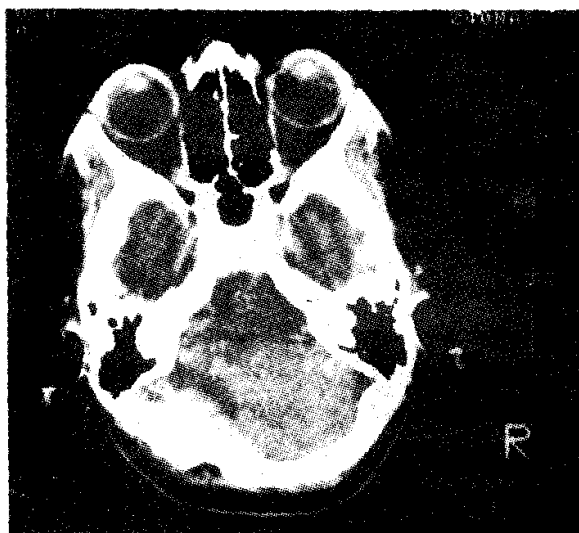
Contrast enhanced axial CT Scan head through the posterior mass on the left side in relation to left cerebellum adjacent to the left occipital bone.
